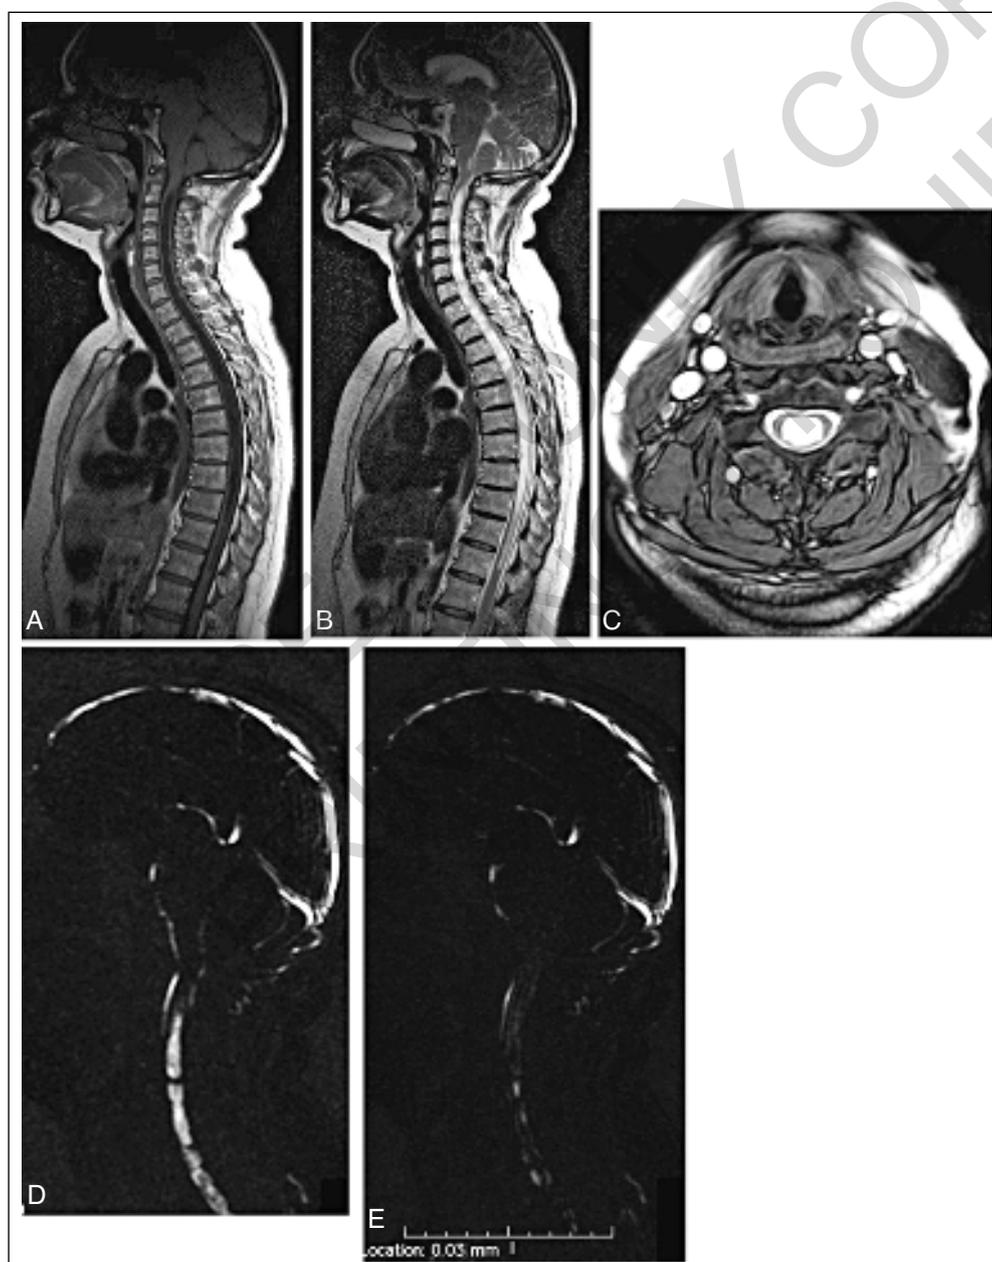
Sagittal T1- (A) and T2-weighted MRI (B) of the brain and spine, and axial T2-weighted MRI (C) (C4-C5 intervertebral disk) showing a Chiari I malformation with a holocord syringomyelia. (D) preoperative Cine phase-contrast MRI during systole revealing the cerebellar tonsils moving downward, the dilation of the syrinx synchronous with the systole, and a CSF jet flow inside the syrinx. (E) Cine MRI performed one month after posterior fossa decompression documenting a significant systolic reduction of flow inside the syrinx.
